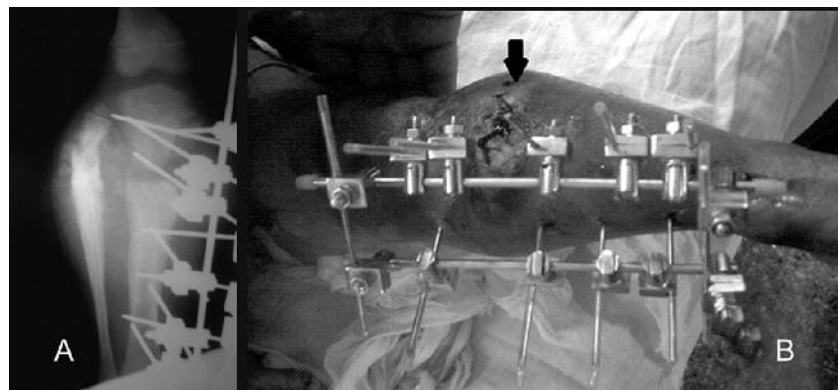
A. Postoperative radiograph showing reduction and stabilization with an external fixator, B. External fixation of fracture proximal both bones left leg with a biplane external fixator. Wound (arrow) after excision of the discharging sinus and debridement can also be seen.
